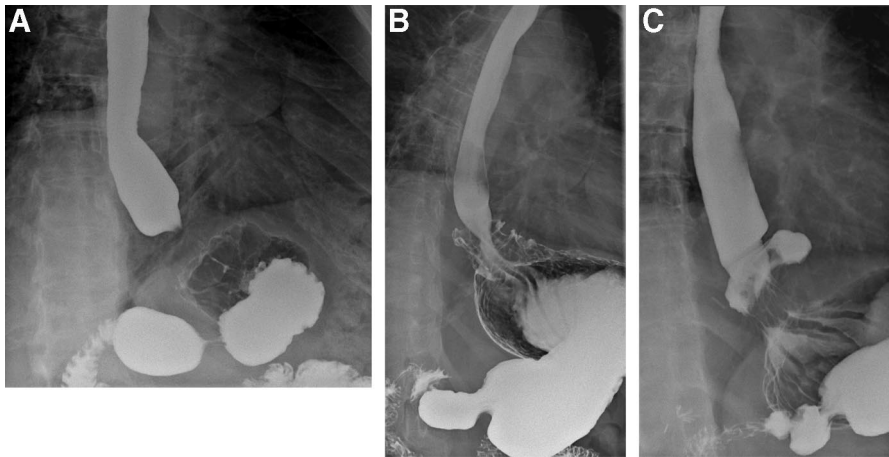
Upper gastrointestinal x-ray postoperative examples. A, Intact fundoplication located below the diaphragm. B, Intact fundoplication, but indeterminate positioning (fundoplication seen within 2 cm of the level of the left hemidiaphragm). C, Intact fundoplication with small sliding hiatal hernia (2–5 cm above the left hemidiaphragm).
